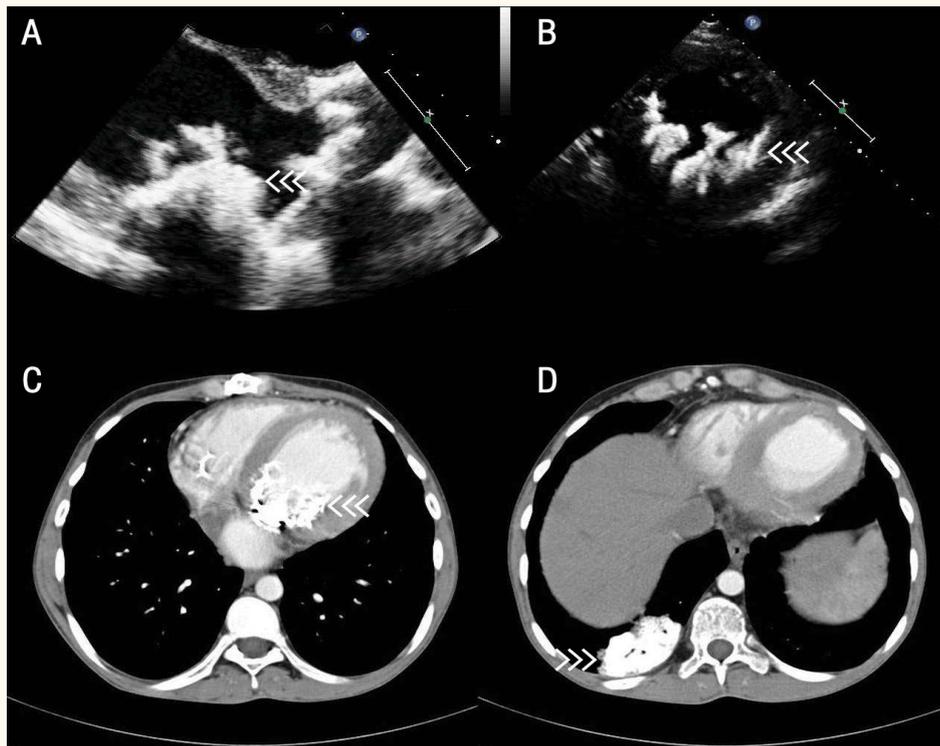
A: Transthoracic echocardiogram (TTE) in parasternal long-axis view showing calcification (arrow heads) of mitral valve prosthesis without involving the discs, extensive calcification of the mitral valve chordae and multiple pedunculated calcific nodular masses seen subvalvularly. B: TTE in the short-axis view showing calcification (arrow heads) of the left ventricular myocardium and part of the interventricular septum. C: Computed tomography (CT) scan of the chest demonstrating cardiac calcification (arrow heads). D: CT scan of the chest showing a lung parenchyma mass of ground-glass nodular calcification (arrow heads) in the right lower lobe.
